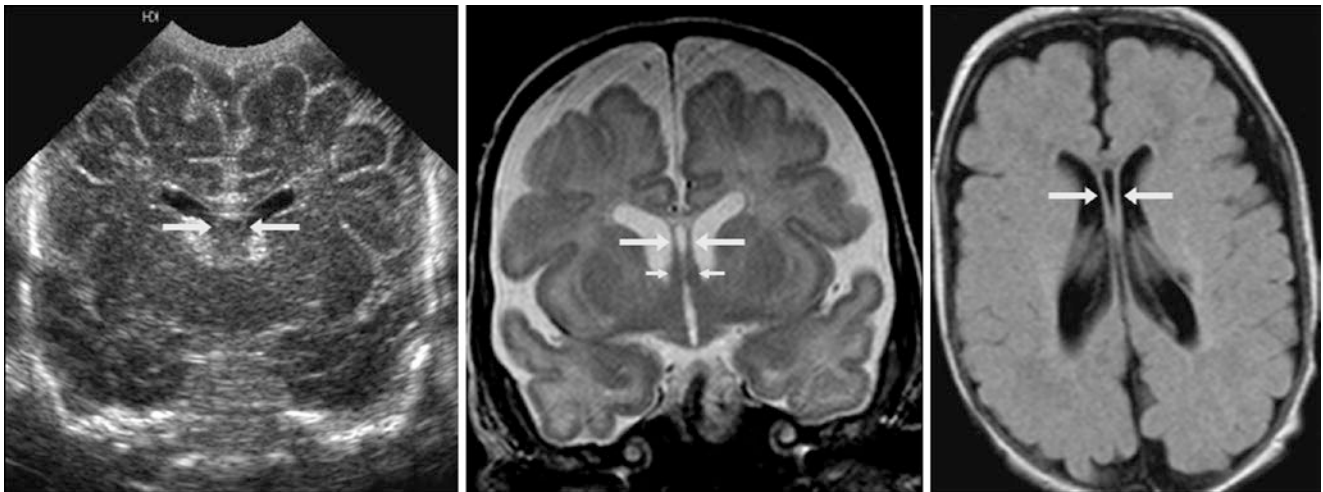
A 3 month old with a CSP (*arrows*) on coronal ultrasound (*left*), T2WI (*middle*), and axial FLAIR (*right*) images. Note the columns of the fornix (*tiny arrows*) on the T2WI. There is also benign
